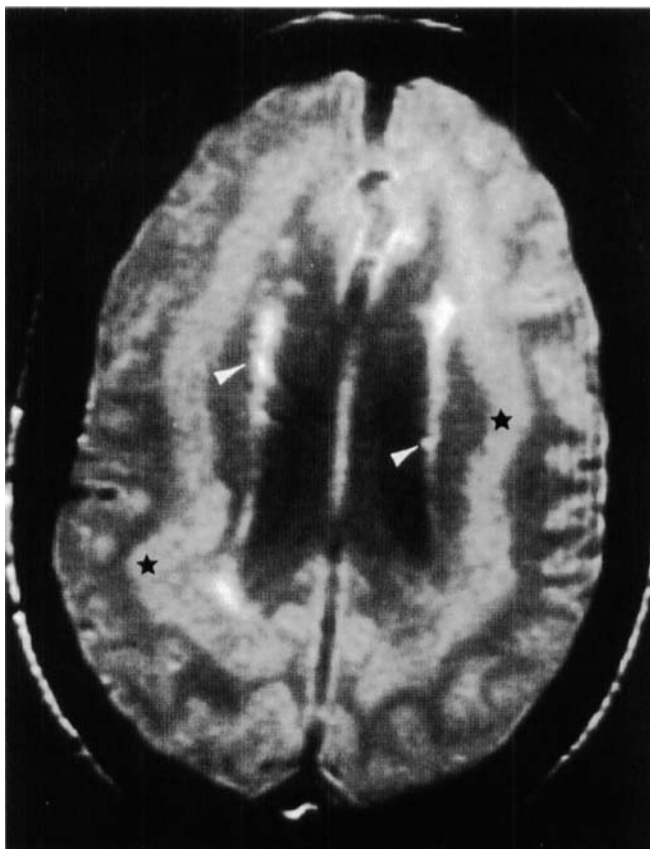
Patient 1 (mother). Bilateral symmetric, moderately thick band heterotopia (black stars) on axial proton density weighted MRI at the level of the bodies of the lateral ventricles. Note that there are also high signal periventricular nodules that are probably age-related vascular abnormalities, but there is a possibility that they are periventricular nodular heterotopia (white arrowheads).
